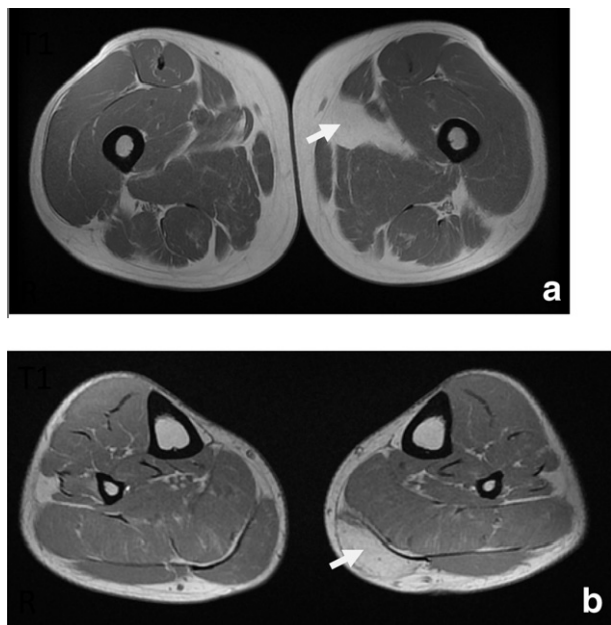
T1-weighted skeletal muscle MRI of the lower limbs: (a) at thigh level, marked fatty infiltration and atrophy of the left long adductor (arrow); (b) at leg level, fatty infiltration of the medial head of the left gastrocnemius (arrow).
